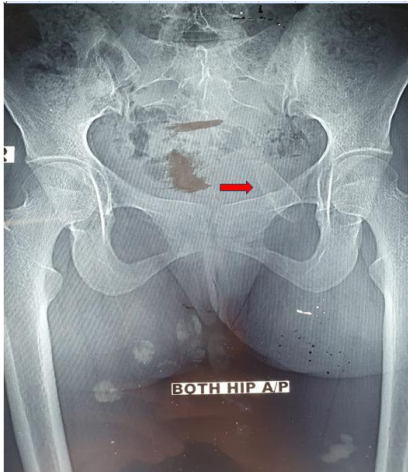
X-ray of the pelvis (A/P view) showing calcification of left sacrospinous ligament.
